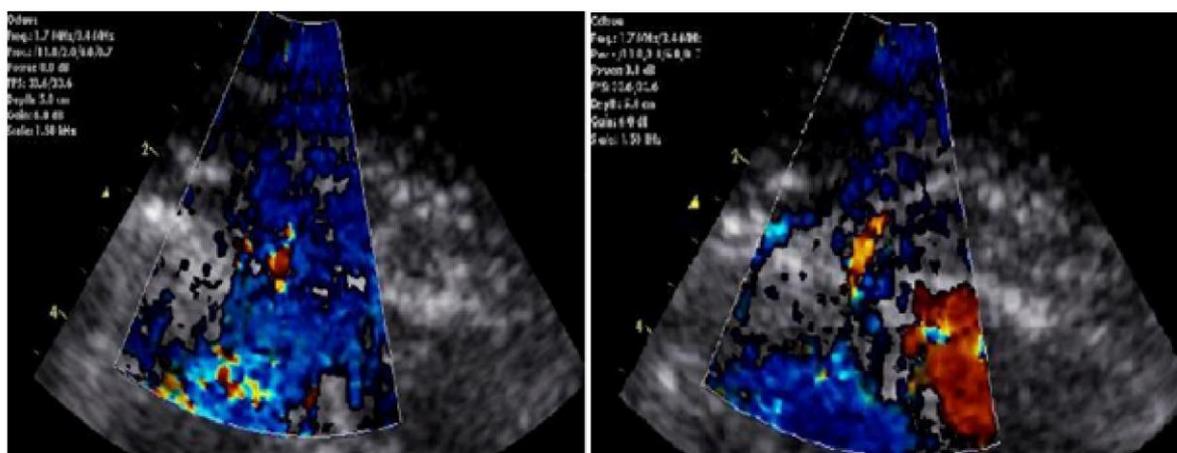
Basal LAD flow* sampling and post-dipyridamole hyperemia LAD flow sampling with transthoracic echocardiography
